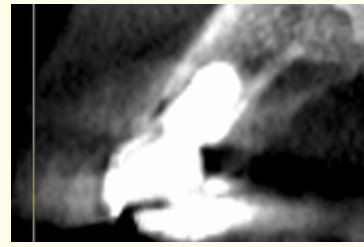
CBCT imaging showing the buccal and palatal bones at the implant level after 5 years in service.
